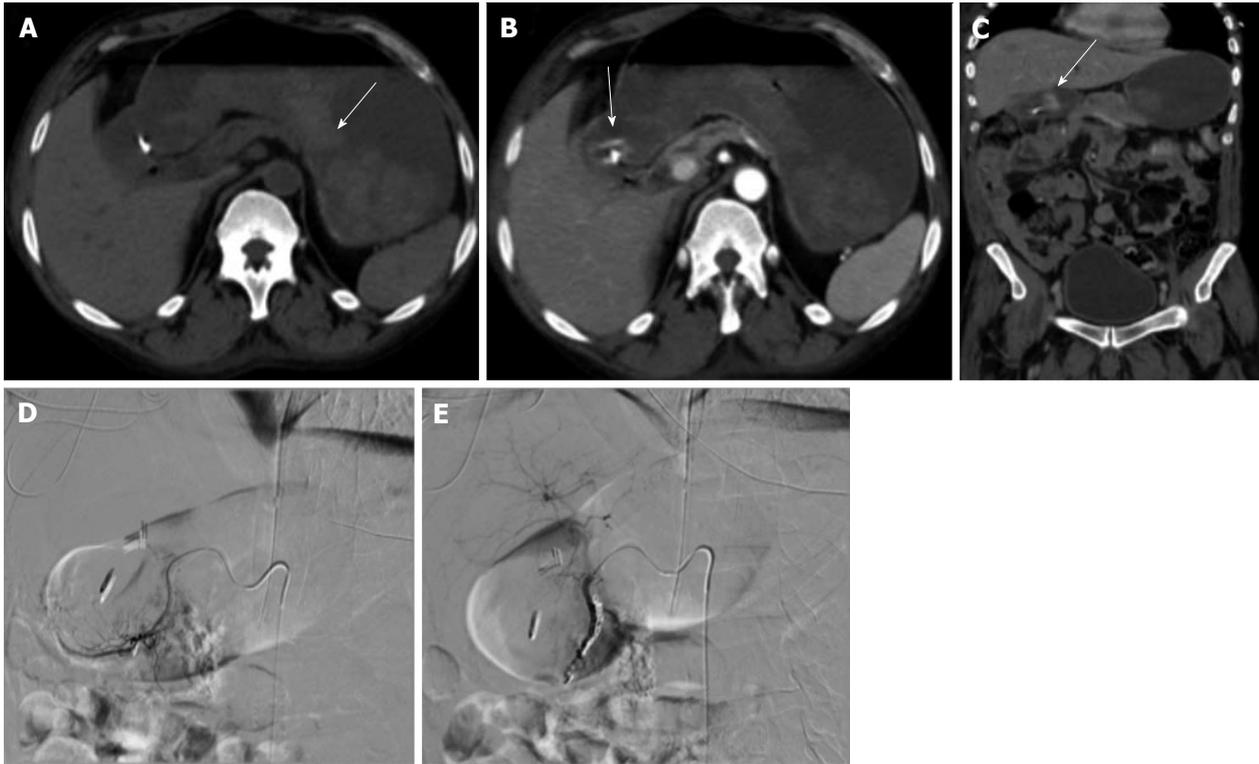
Upper gastrointestinal bleed secondary to gastric/duodenal ulcers. Fifty-four-year-old male with history of gastric ulcers which were treated by clipping through endoscopy. Despite endoscopic intervention, the patient presented with dropping hematocrit requiring transfusion. A: Noncontrast; B and C: contrast enhanced computed tomography imaging demonstrates active extravasation at the level of the gastric antrum with blood product filling the stomach; D and E: Active extravasation was found at the gastroduodenal artery (not shown) which was embolized with coils and gelfoam.
